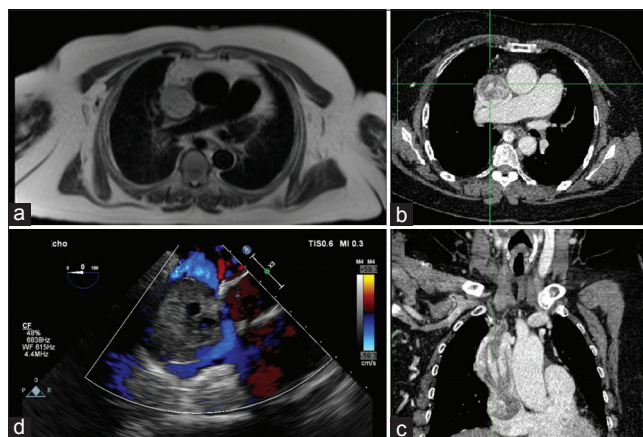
Combo images showing the tumor thrombus in relation to the heart in axial T1-sequence magnetic resonance imaging thorax (a), axial view of contrast-enhanced computed tomography thorax (b), coronal view of contrast-enhanced computed tomography thorax (c) and transesophageal echocardiogram (d)
